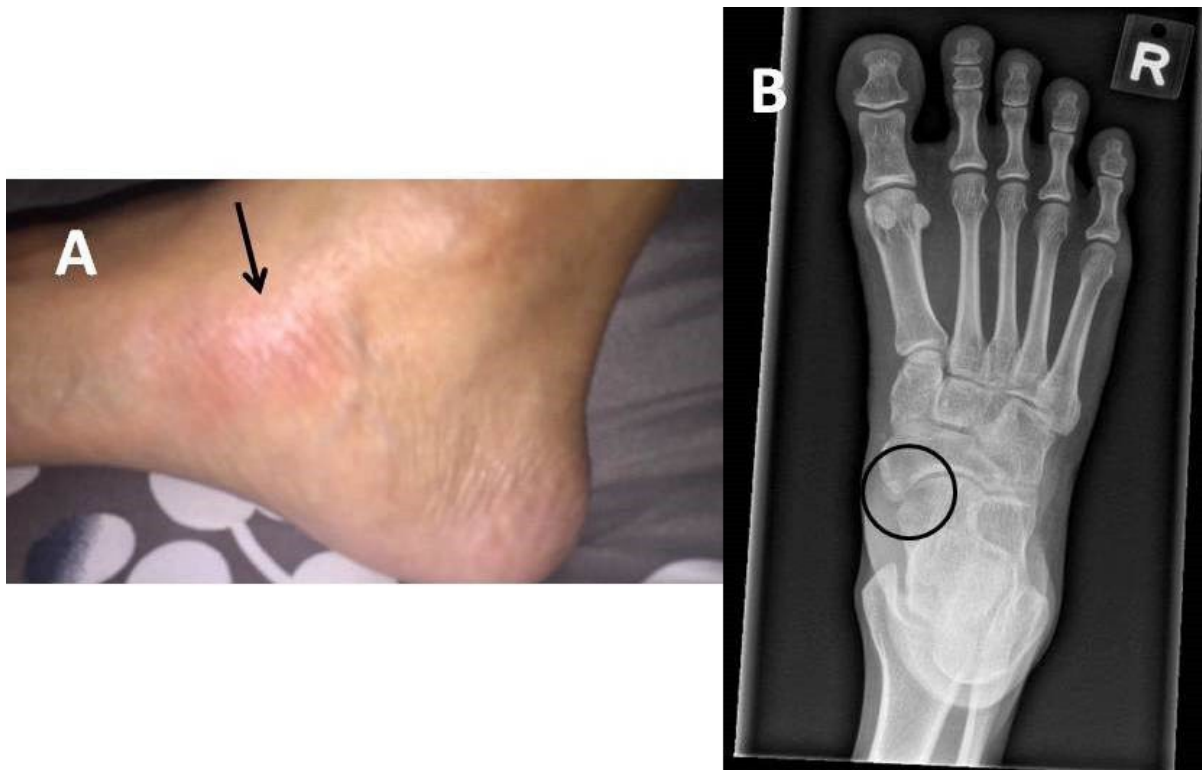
(A) Image of right foot showing localized erythema and swelling over the medial aspect of the right mid-foot (arrow) and (B) X-ray of right foot showing accessory navicular bone (circle)
